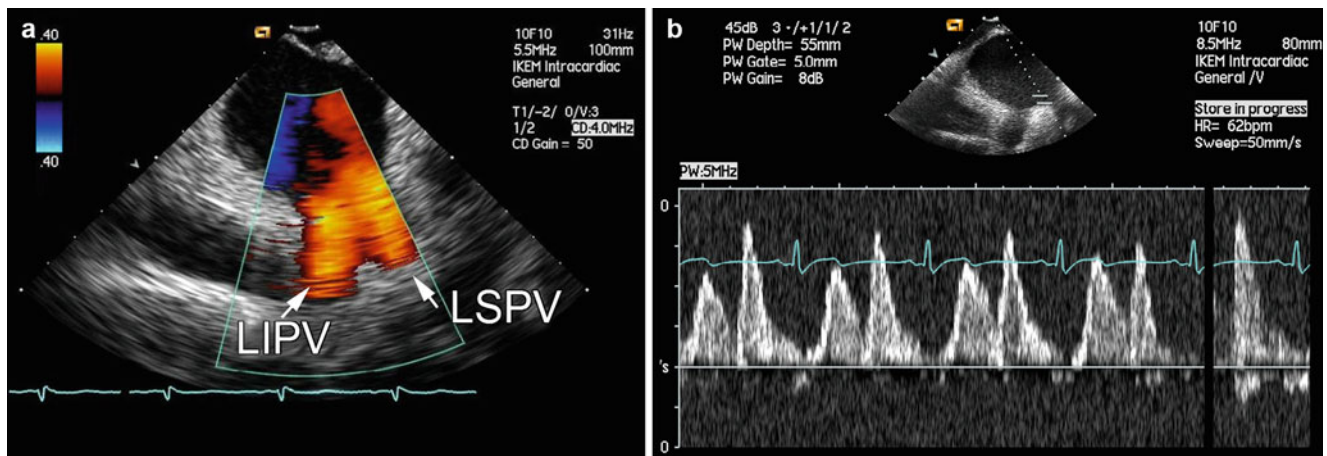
Examples of Doppler evaluation of pulmonary veins. (a) Color Doppler depiction of flow in the left superior (LSPV) and inferior (LIPV) pulmonary vein. (b) Flow in the LSPV obtained by pulsed Doppler imaging
